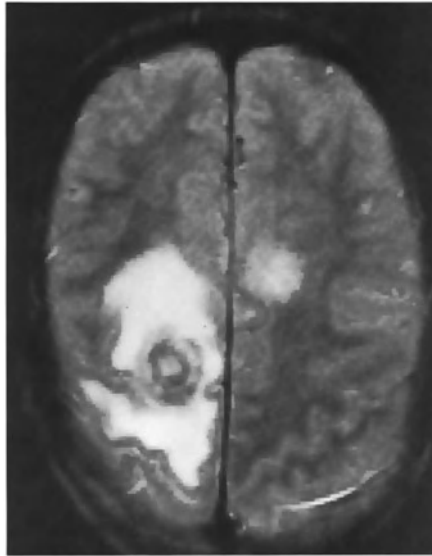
Primary CNS lymphoma. T<sub>2</sub>-weighted axial MR image in this AIDS patient shows two lesions with markedly different signal characteristics. The right hemispheric mass has a target-like appearance; the central area of T<sub>2</sub>-shortening is thought to be due to the high nuclear to cytoplasmic ratio of the tumor cells. Also note the marked peritumoral edema (TR = 2000, TE = 80)
